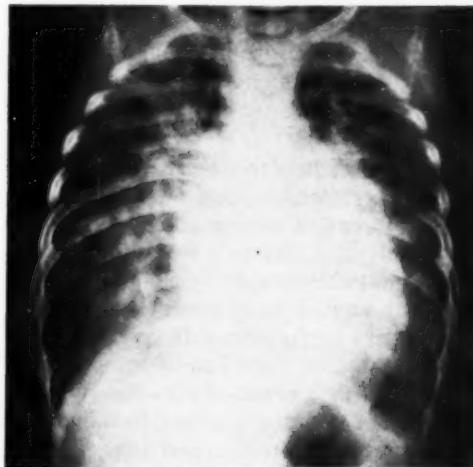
Case VII. Roentgenogram at seven months of age, showing cardiac enlargement, marked vascular congestion, and bilateral emphysema. Infant expired three weeks later.
